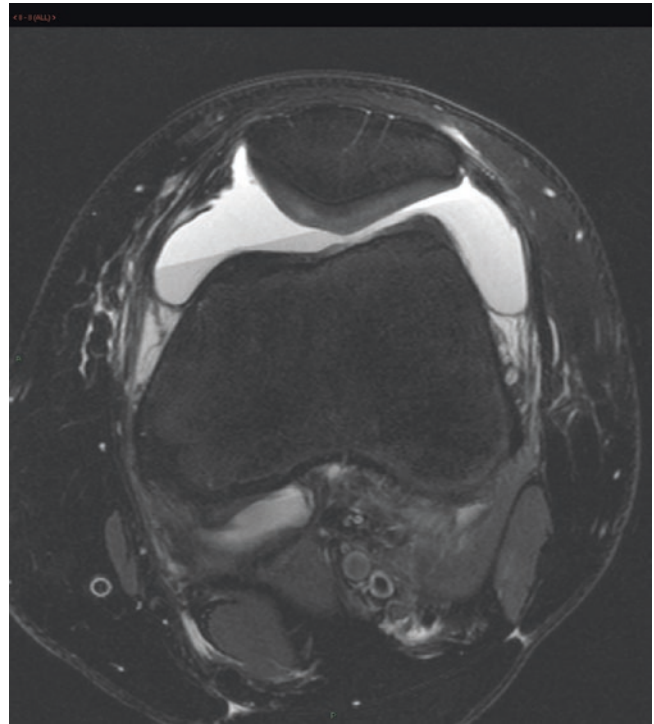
Axial proton density MRI of the knee demonstrating fat-fluid level, with blood products lying dependently
